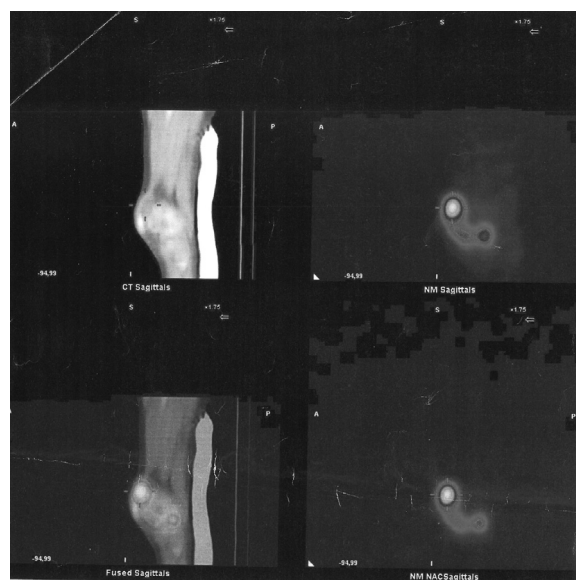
Axial, coronal and sagittal SPECT/CT images showing focal accumulation of Y-90 in the suprapatellar recess of a patient.
